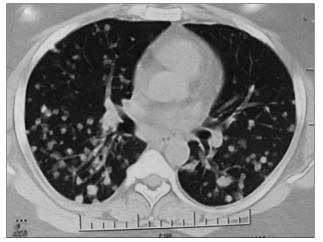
Computed tomography chest showing diffuse nodular pattern of melioidosis in both the lungs
